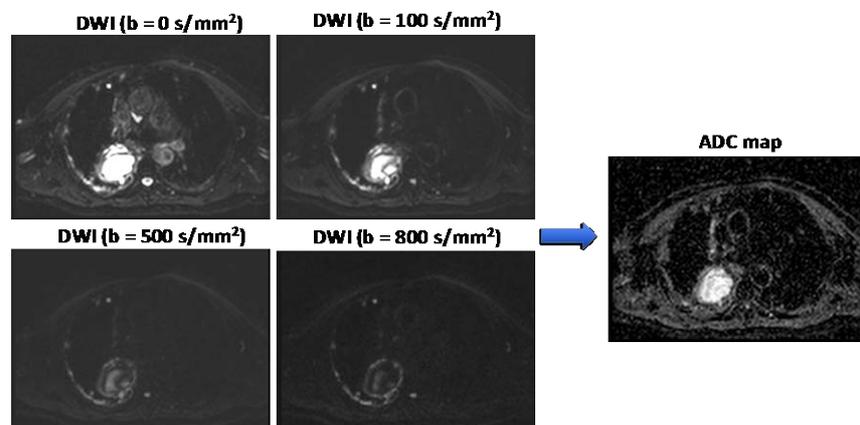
The DWI images at multiple b-values and the derived ADC map of a 74-year-old male patient with malignant pleural mesothelioma in the right lung comprising both cystic and solid disease.
